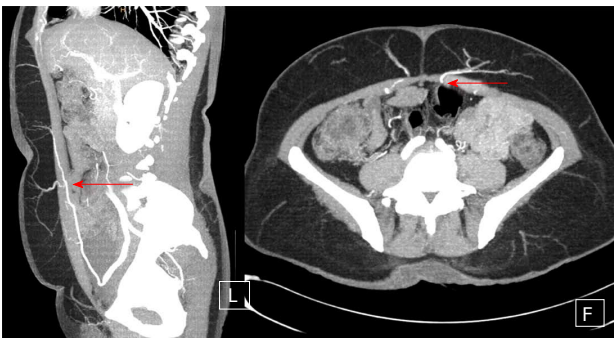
Computed tomographic-angiography to better elucidate the exact anatomy of perforators of the deep inferior epigastric perforator-vessels. The red arrow points out the piercing of the perforator through the rectus abdominis muscle on the sagittal (left) and transverse (right) view.
